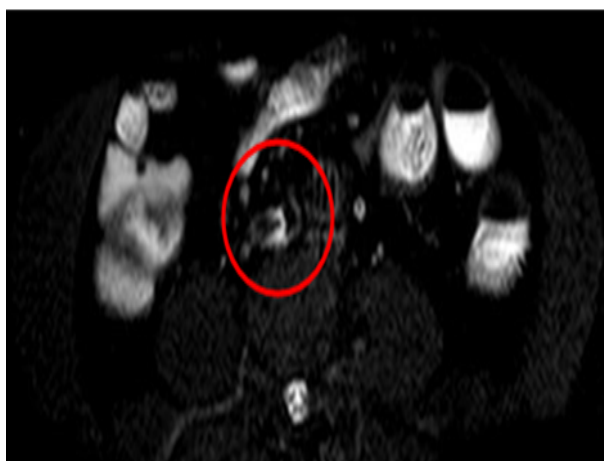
Neoformation vessels on the right inferior rectal artery, in MRI with multicenter condensing processes, characteristic for stage 3 EMVI
